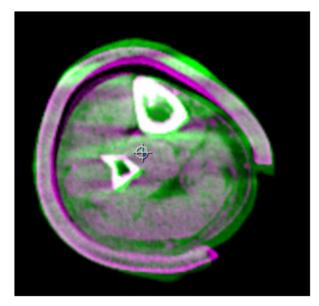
CBCT left leg Fraction 19.
